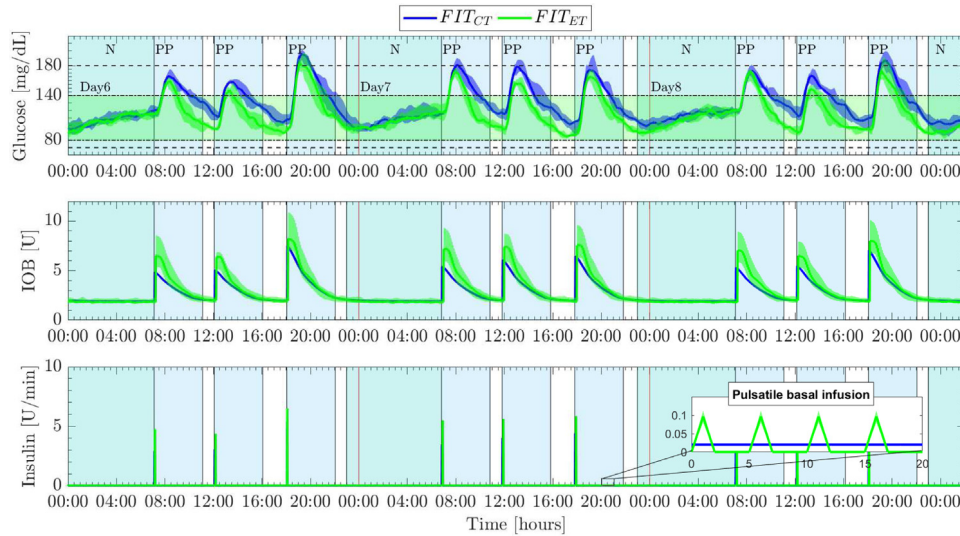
Comparison of the event-triggered scheme (FIT_{ET}) respect to conventional therapy (FIT_{CT}) under perfectly announced meal case. Blood glucose, IOB and insulin profiles are shown in terms of median (solid lines) surrounded by colored regions representing the [25th, 75th] percentiles.
